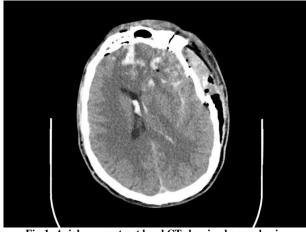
Axial non contrast head CT showing hemorrhagic contusions in the frontal lobes in conjunction with posttraumatic subarachnoid and intraventricular hemorrhage
